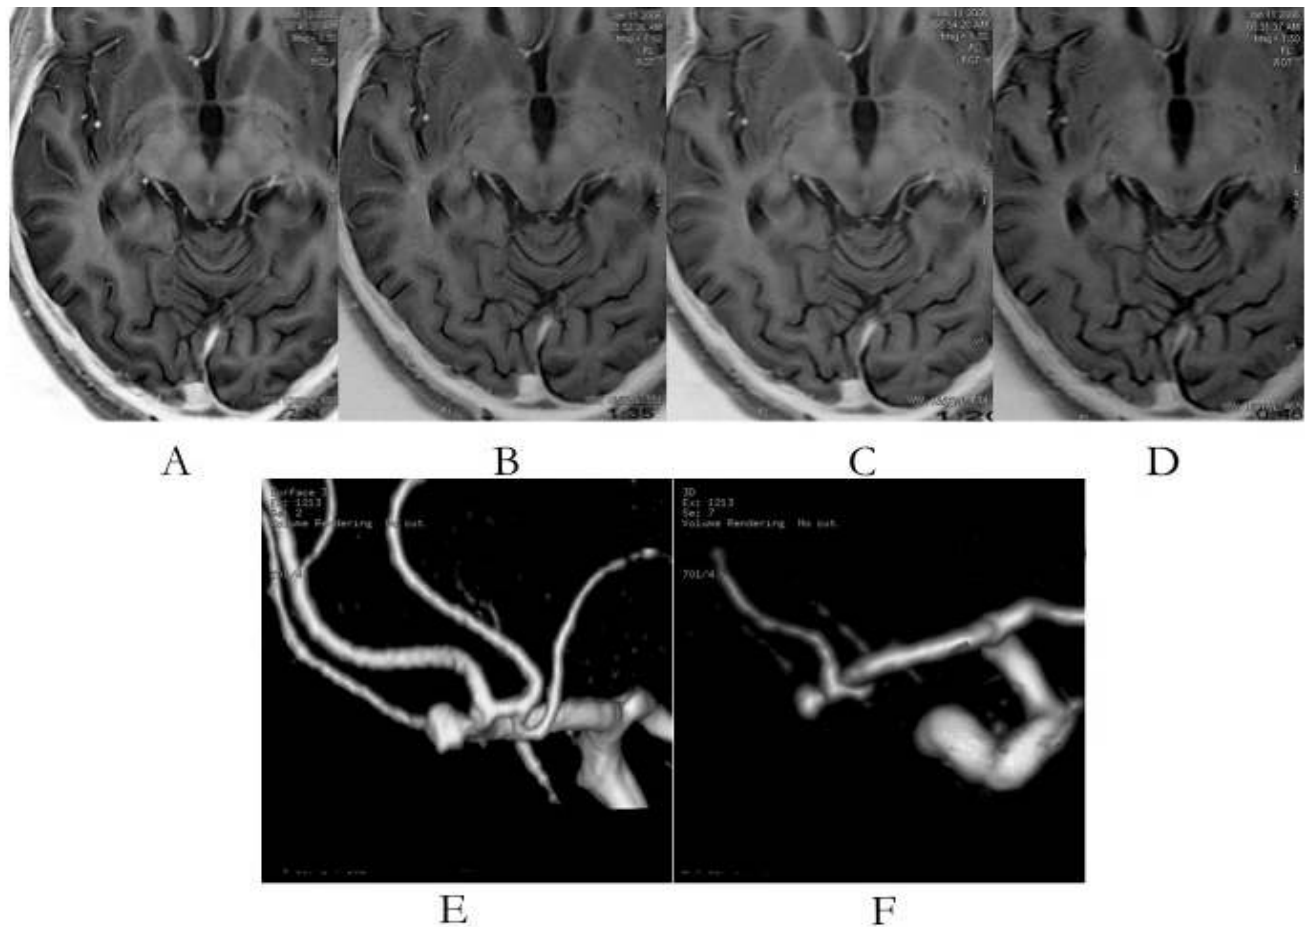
(A) STIR (with short-inversion-time inversion recovery) image, (B) STIR images of a case of AVM, (C) High resolution MRA and MRA volume rendering of the aneurysm case, (D) FLAIR image of a case of SAH
